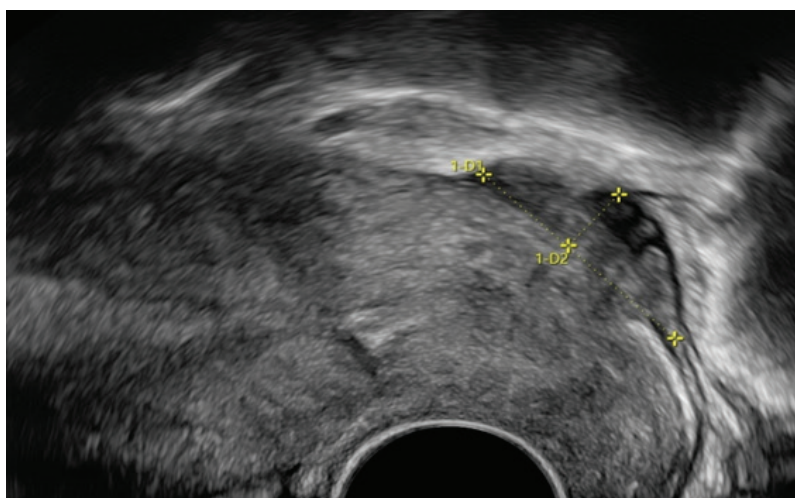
A 2D Sonographic imaging showing the hypoechoic, irregularly contoured rectal nodule measuring $2.72 \times 0.8 \times 1.75$ cm, located in the anterior rectal wall. The lesion appears infiltrative with posterior shadowing, consistent with deep endometriosis.
